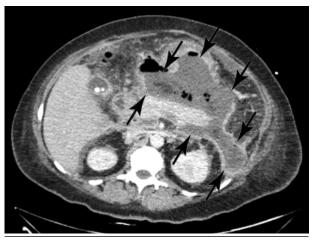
Abdominal CT scan with contrast on January 10, 2022: a fluid/necrosis collection is indicated by the black arrows; the delineation and the wall of the collection are clearly visualized
